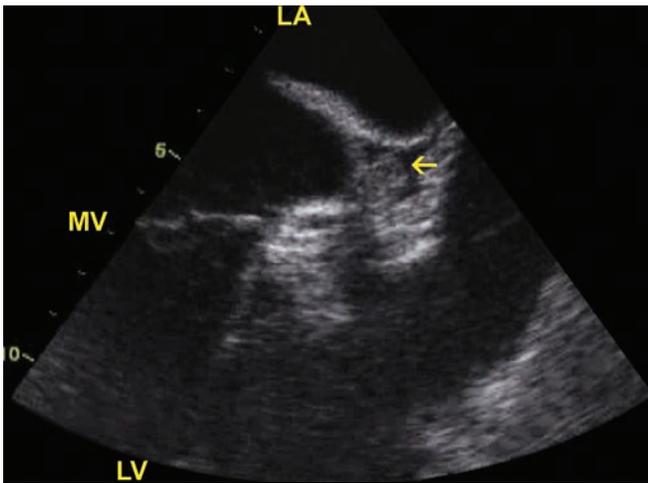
Transesophageal echocardiography. Arrow points to left atrial appendage thrombus measured 0.8×1.2 cm.
